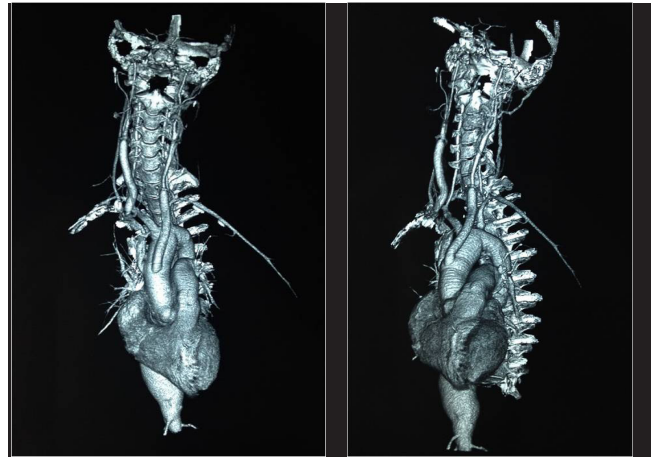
Postoperative 3D reconstructed CTA demonstrated patent grafts in ascending aorta and bilateral common carotid arteries(A,B).
